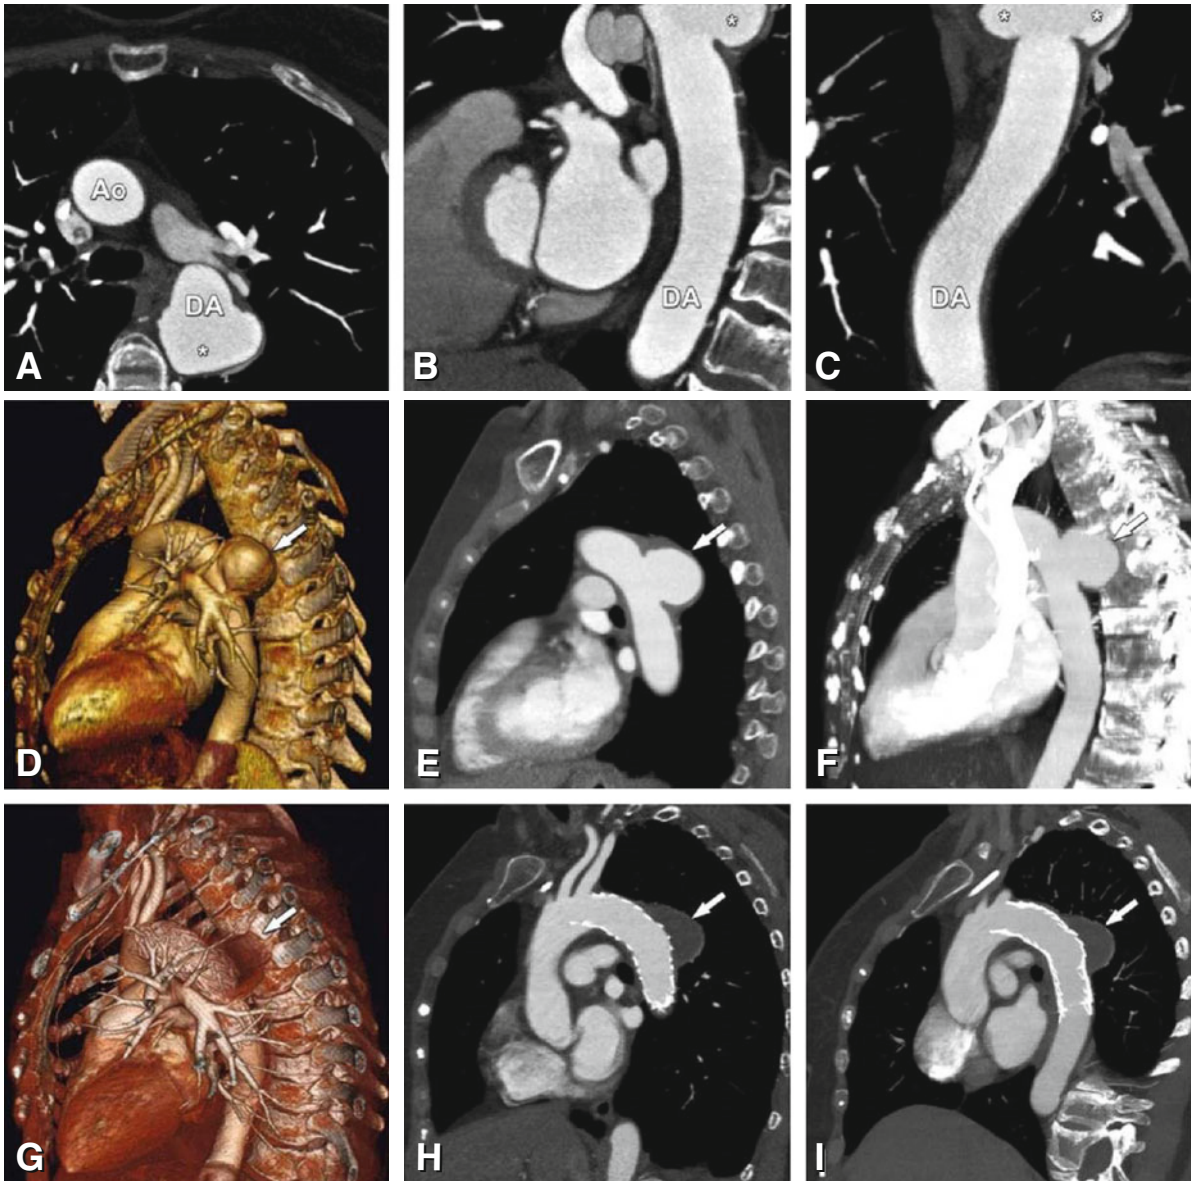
Saccular aneurysm of the descending thoracic aorta in a 65-year-old female patient. On the most cranial slices of coronary CT angiography, a focal excentric dilatation (4.3 cm, *asterisks in Panels A–C*) of the descending aorta (DA) is partially visible. Panel A represents an axial source image, and Panels B and C represent double-oblique sagittal and coronal slices. Because of this extracardiac finding, CT angiography of the thoracic and abdominal aorta was subsequently performed. This test confirmed the focal saccular aneurysm, which did not extend to the aortic arch (*arrow in Panels D–F*, lateral views). Percutaneous interventional treatment with stenting was performed, and follow-up CT scans showed that the stent excluded the aneurysm well, resulting in thrombosis and exclusion from perfusion of the aneurysm (*arrow in Panels G–I*, lateral views). The suprarenal location and the absence of atherosclerosis in other vascular territories indicate that this was most likely a mycotic aneurysm. Ao aorta
